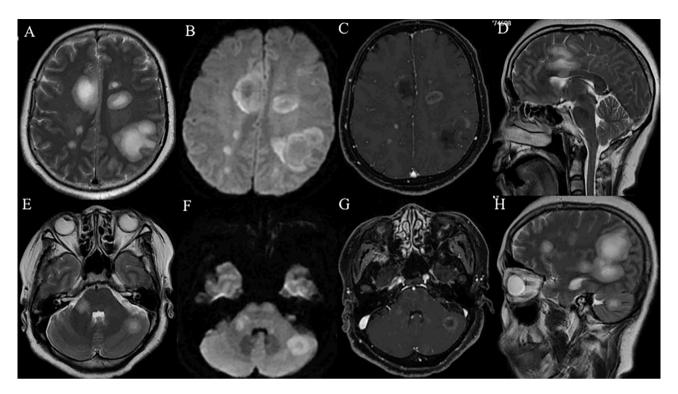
Patient 4 with acute disseminated encephalomyelitis in a 52-year-old female. Axial T2 (A and E) and DWI (B and F) images show multifocal hyperintense lesions, the left cerebellar hemisphere and the right brachium of the pons. Axial postcontrast T1-weighted images (C and G) reveal mild contrast enhancement of the abnormalities. Sagittal T2-weighted image (D and H) shows patchy hyperintensity at the frontoparietal temporal lobe
